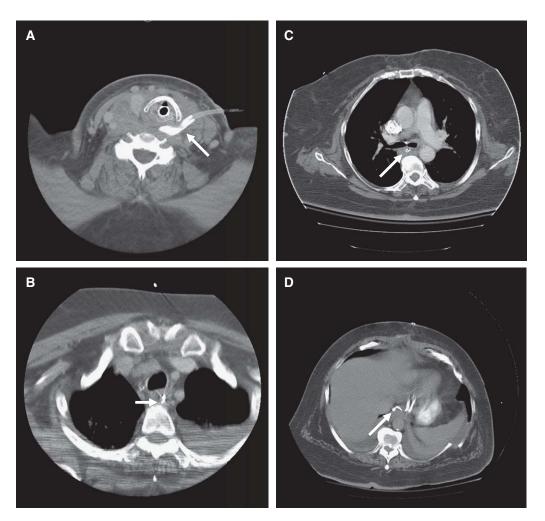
Computed tomographic scan after transhiatal decompression. Drains (*arrows*) placed via (A) the left cervical and an upper abdominal incision are seen traversing the mediastinum: cervical (A), thoracic inlet (B), carina (C), and diaphragm (D) (all drains were extraluminal within mediastinum).
